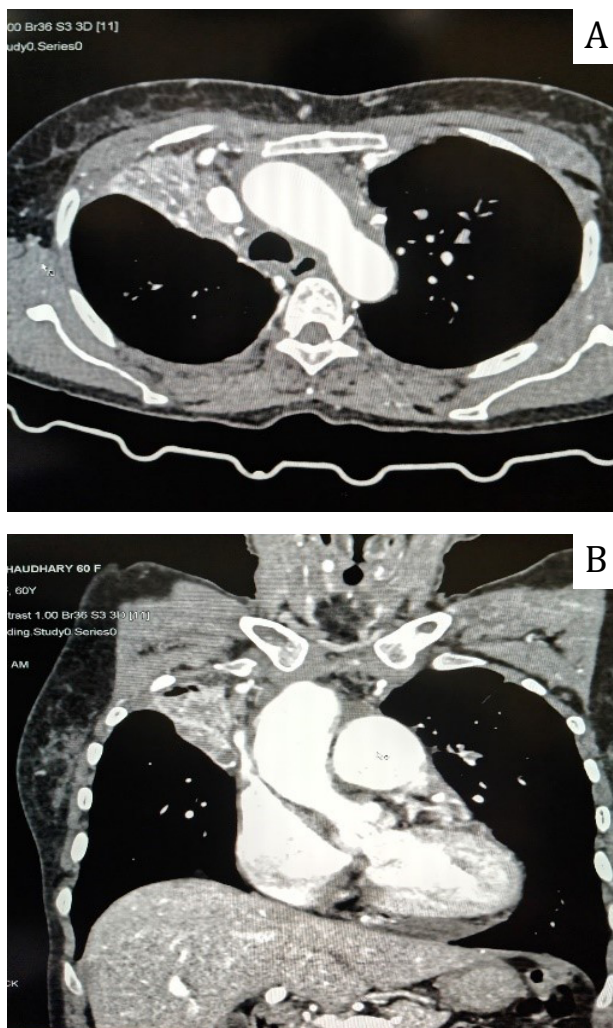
(A, B, C): Computerized Tomography (CT) scan of the chest in Axial, Coronal, and sagittal views showing an ill-defined hypo-enhancing lesion in the right suprahilar region with heterogeneously enhancing lymph nodes in the right hilar and bilateral paratracheal region.
